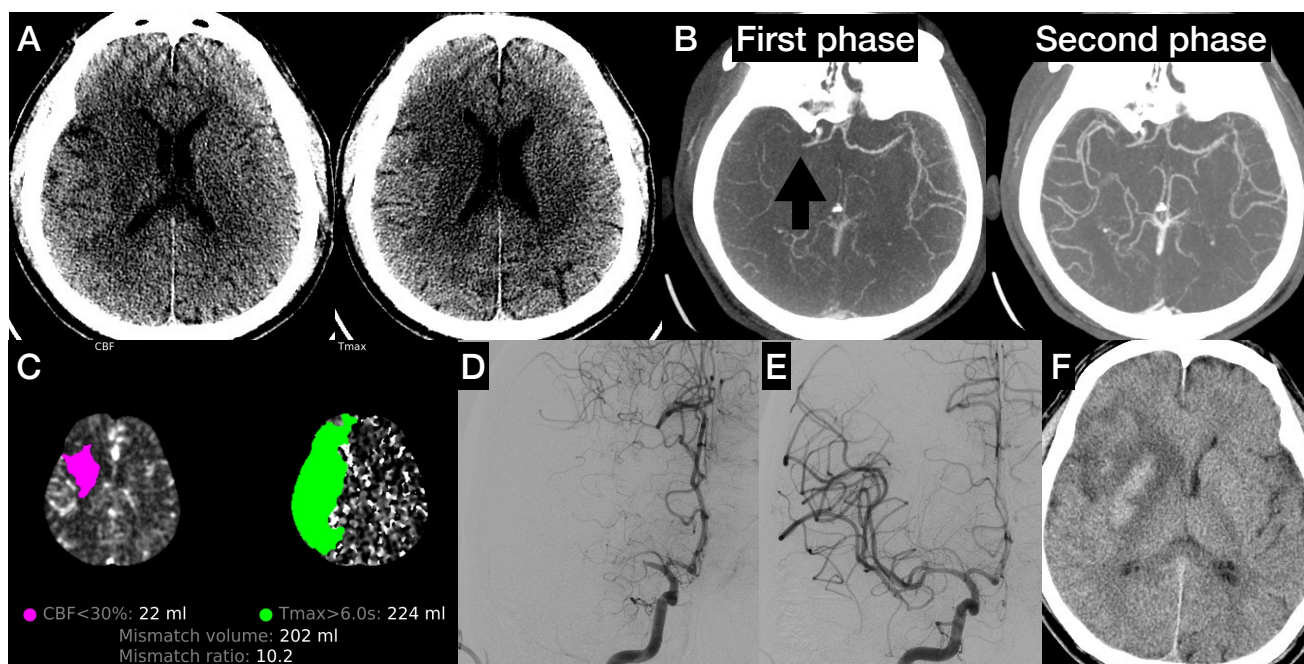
A 55 years old patient presenting left-sided weakness upon waking up, NIHSS = 10. A: NECT of the brain shows a hypodense area in the right caudate nucleus, lentiform nucleus, internal capsule, insular cortex, M1 and M4 areas, and an ASPECTS score = 4. B: Multi-phase CTA in the 1st and 2nd phases shows total occlusion at M1 segment of the right MCA (black arrow) with collateral score = 4. C: CT perfusion shows a small area of core infarct, 22 ml, with a large ischemic penumbra area, mismatch ratio = 10.2. Based on the DEFUSE-3 criteria from CT perfusion, the patient was sent for MT. D: Right ICA angiogram shows total occlusion of the M1 segment of the right MCA. E: Post-MT right ICA angiogram shows recanalization of the right MCA. F: CT of the brain 24 hours after MT showed hemorrhagic transformation in the right basal ganglia. However, the patient improved in weakness, NIHSS = 2. At the 3-month follow-up, the patient showed mRS = 2.
